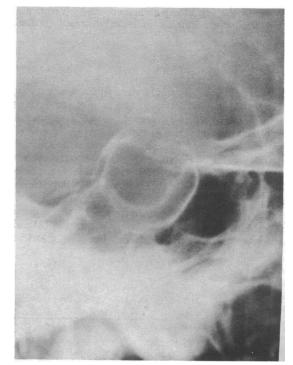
Lateral radiograph showing eccentric expansion of the sella.
